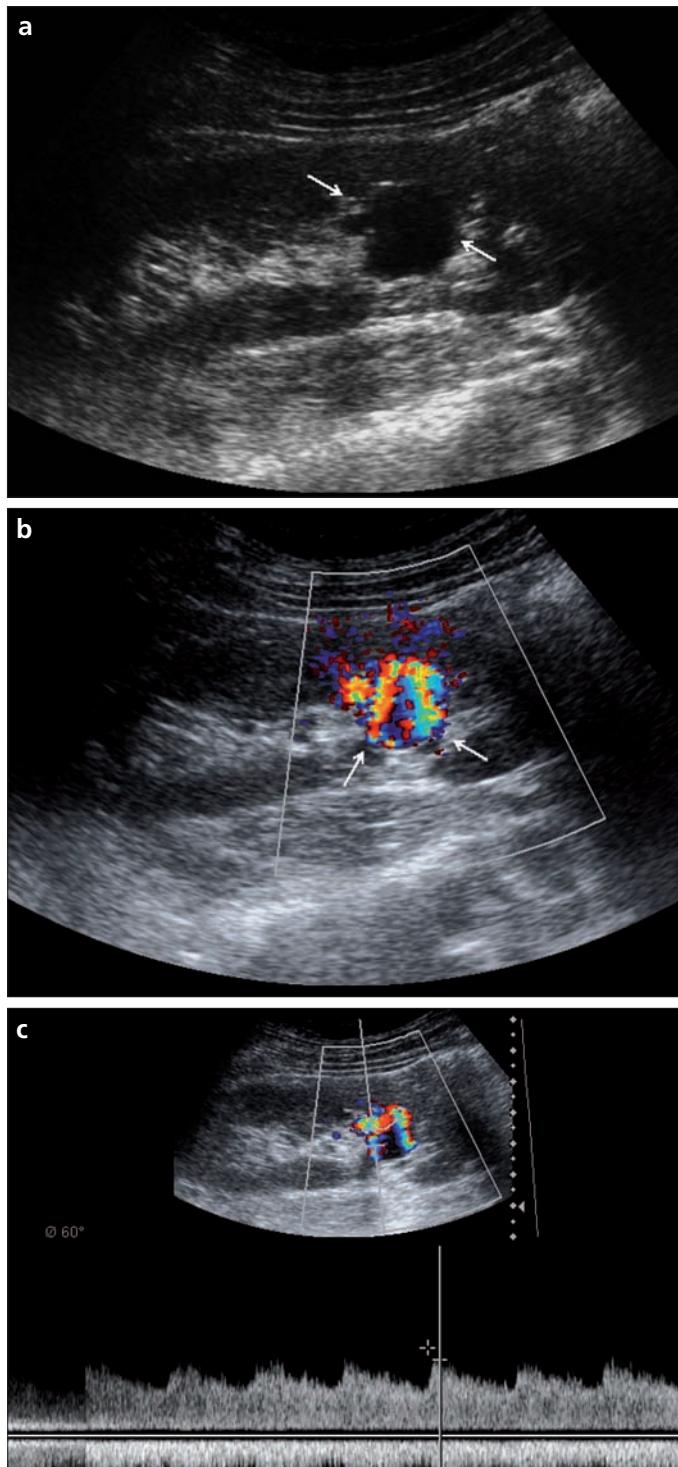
a-c. On gray-scale ultrasound (a), a cyst-like lesion at the inferior pole of the kidney is seen (arrows), which has heterogeneous fill-in on color Doppler ultrasound (b, arrows). Spectral analysis (c) shows turbulent flow with increased flow velocity of 229 cm/s.
